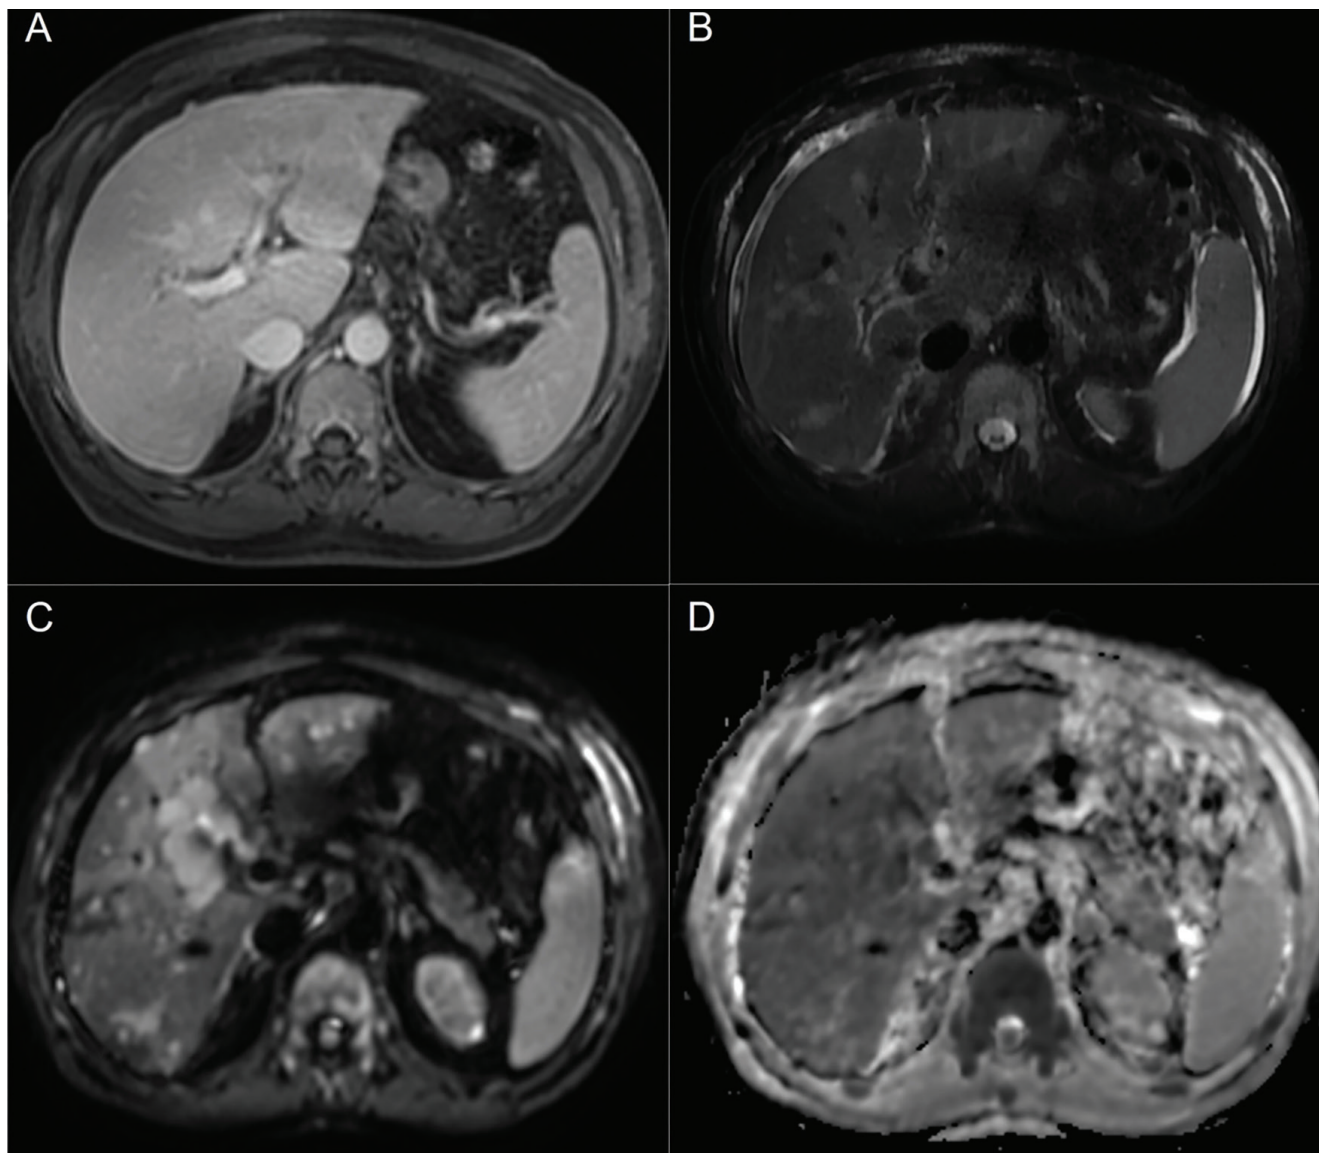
Liver magnetic resonance imaging demonstrating diffuse hepatic infiltration in multiple myeloma 2A. Axial contrast-enhanced T1-weighted image shows heterogeneous parenchymal enhancement without discrete focal lesion 2B. Axial T2-weighted image demonstrates hepatomegaly with heterogeneous, mildly increased parenchymal signal intensity without discrete focal lesions 2C. Diffusion-weighted image ($b=800$) shows heterogeneous parenchymal hyperintensity without discrete focal lesions 2D. Apparent diffusion coefficient map shows diffusely reduced signal intensity, supporting restricted diffusion in keeping with diffuse plasma-cell infiltration. As previously reported in the literature, magnetic resonance images findings of diffuse hepatic myeloma may be subtle and non-specific, often manifesting as heterogeneous parenchymal signal alterations without discrete mass formation (3,4).
